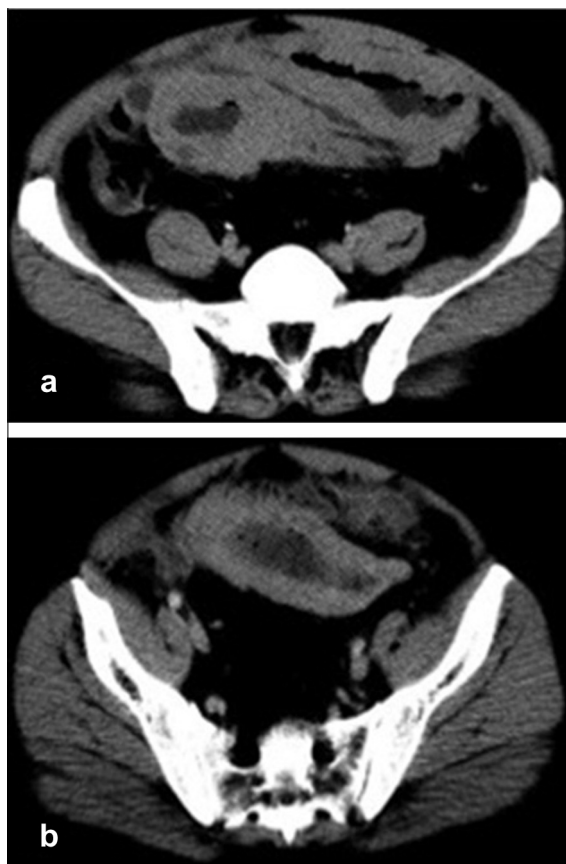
Forty three year old male recipient one year post LDLT complained of repeated vomiting, fever and continuous abdominal pain. (a & b) Axial CT images of the pelvis showing diffuse mural thickening of the small bowel loops. Non-Hodgkin lymphoma was proved by biopsy and pathology.
